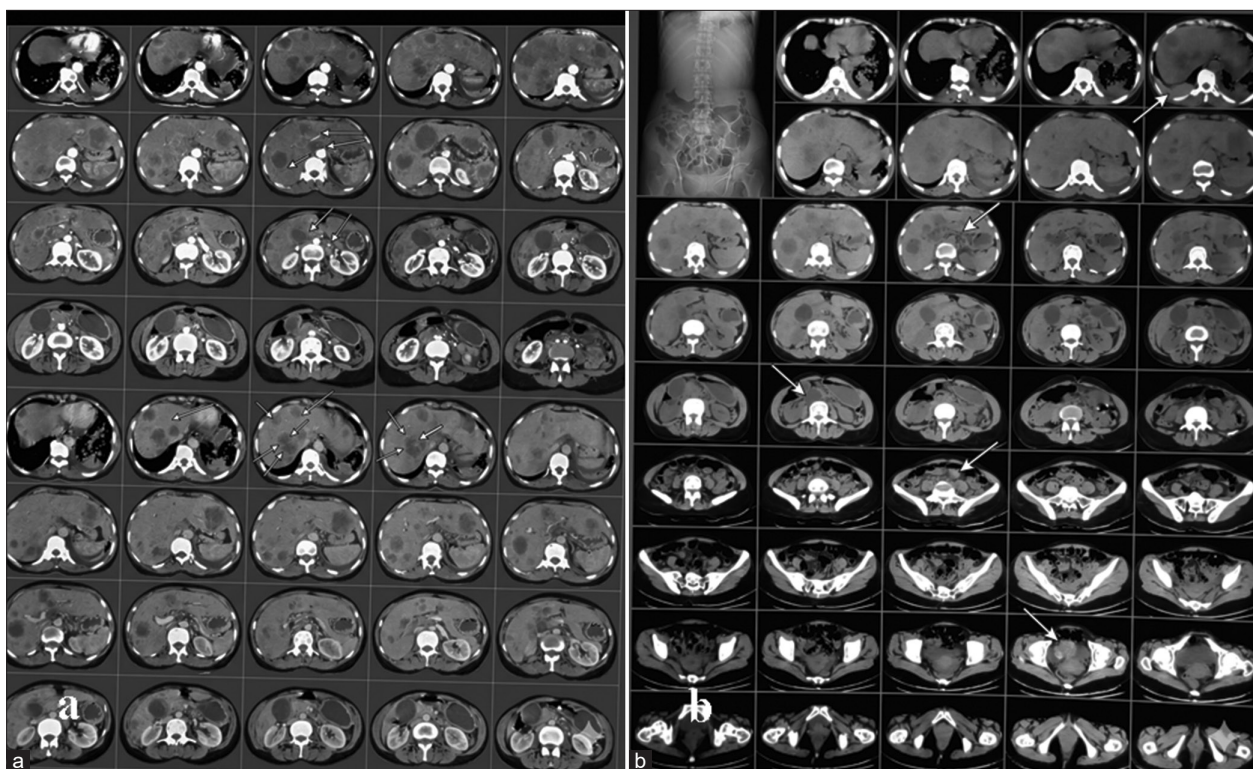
(a) Triphasic computed tomography (CT) abdomen: Multiple peripherally enhancing hepatic nodules with inner cystic change bilaterally; largest 35×31 mm (arrows) (b) CT abdomen/chest: Common bile duct widening to 6 mm with diffuse wall thickening, bilateral pleural effusion, and left basal soft-tissue lesion (arrows)
